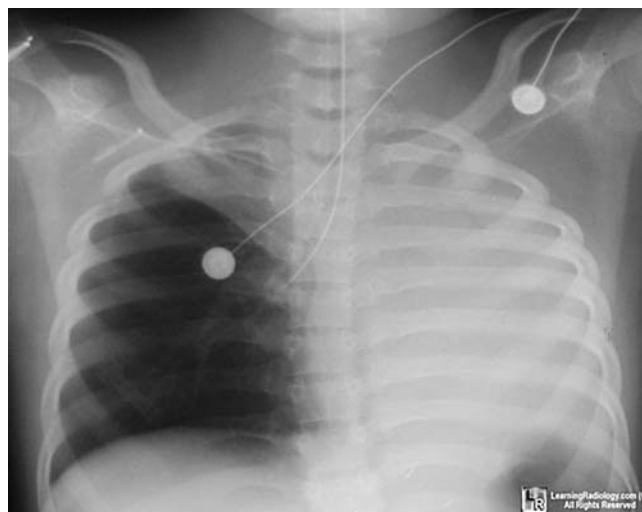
Chest radiograph showing the tip of the endotracheal tube in the right main-stem bronchus. This case of right endobronchial intubation is complicated by left lung atelectasis. (Reproduced, with permission, from William Herring MD, www.learningradiology.com. Published with permission from LearningRadiology.com.)
